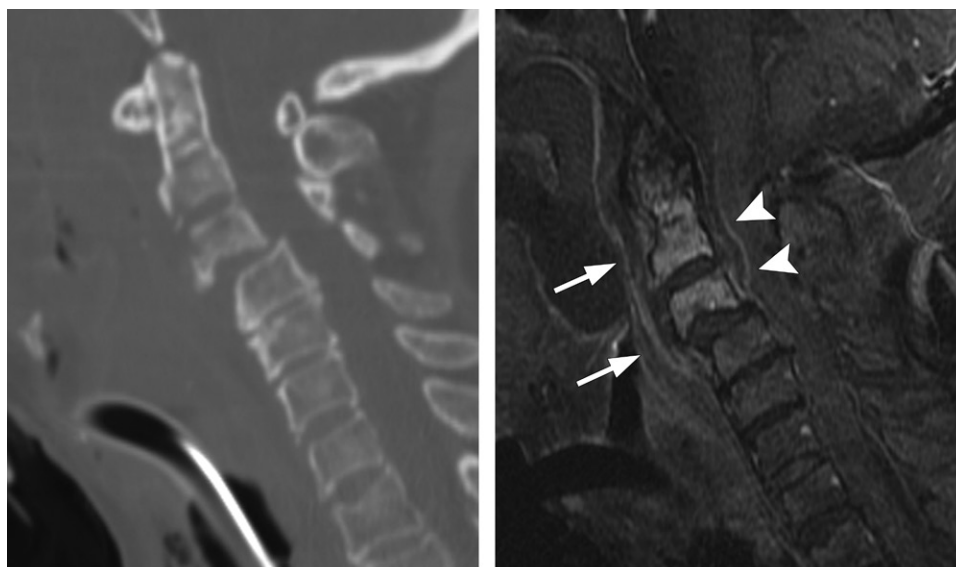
Osteoradionecrosis (ORN) of the spine in a 79-year-old woman with neck pain, ulceration of the posterior pharyngeal mucosa, and fever. She developed chronic nasopharyngitis after chemoradiation therapy (CRT) (standard-fractionation type) for malignant lymphoma of the oropharynx 9 years earlier. (a) Sagittal CT image (bone window) shows irregular endplate destruction and mild bone collapse of the upper cervical spine and C3-C4 spondylolisthesis. (b) Sagittal contrast-enhanced fat-saturated T1-weighted image shows enhancement of C2 and C3. Also noted are retropharyngeal edema and effusion at the posterior pharyngeal wall (arrows) and along the ventral portion of the cervical cord (arrowheads).
